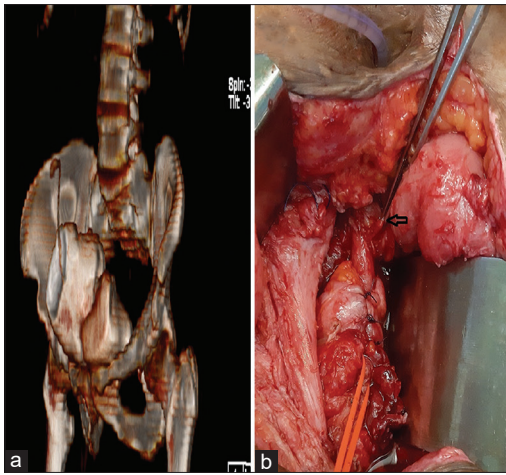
(a) Three-dimensional computed tomography reconstruction showing Yang-Monti channel attached to the augmented segment of the urinary bladder. (b) Buttressing wrap around Yang-Monti tube at the bladder end with 3 interrupted sutures along with the rectus fascia sling in the mid-segment (arrow)
